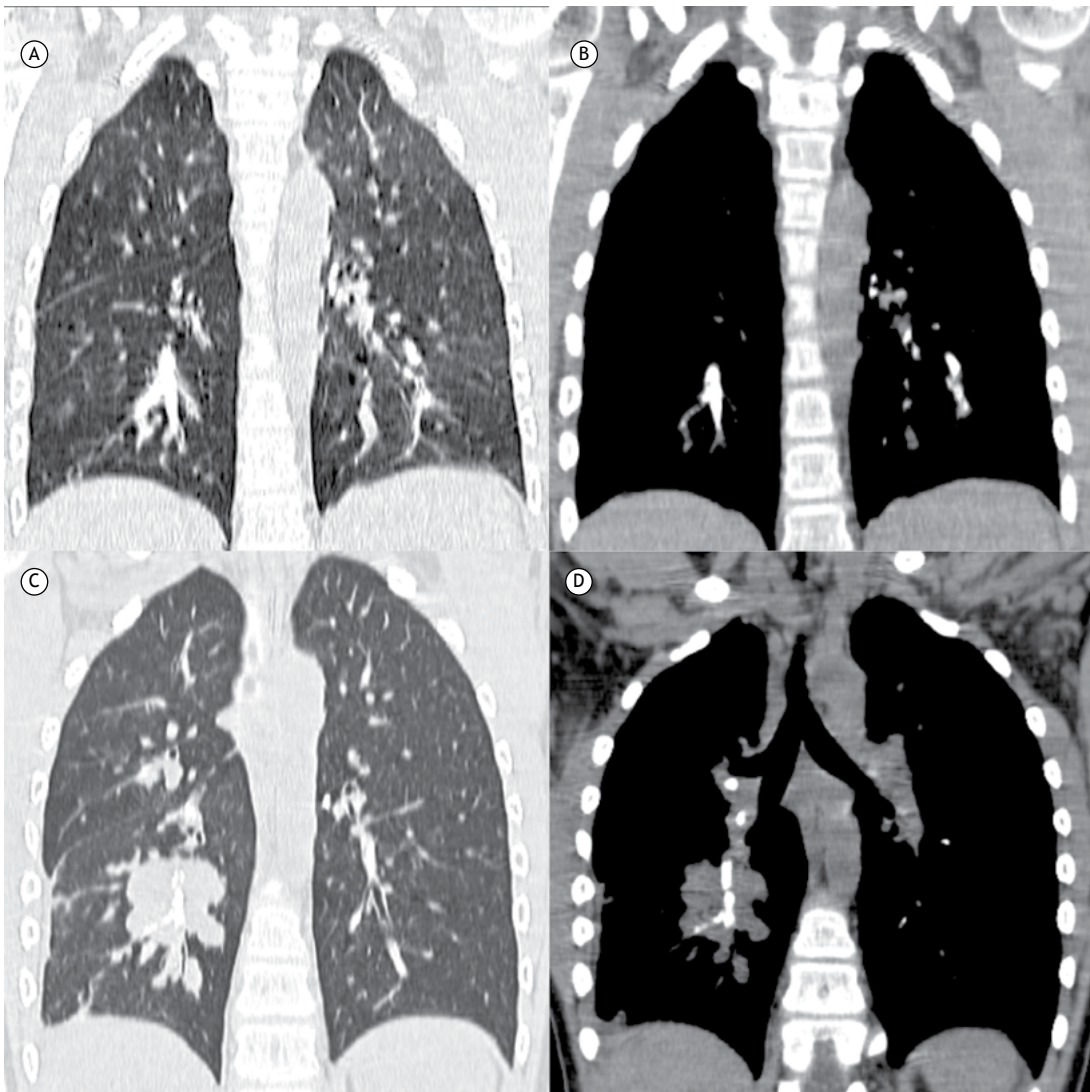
A 7-year-old boy with primary osteosarcoma of the femur. In A and B, CT scans showing calcified intravascular lung metastasis, which was confirmed by biopsy. In C and D, CT scans acquired 6 months later, showing progression of the lung lesions, with mass formation on the right.
